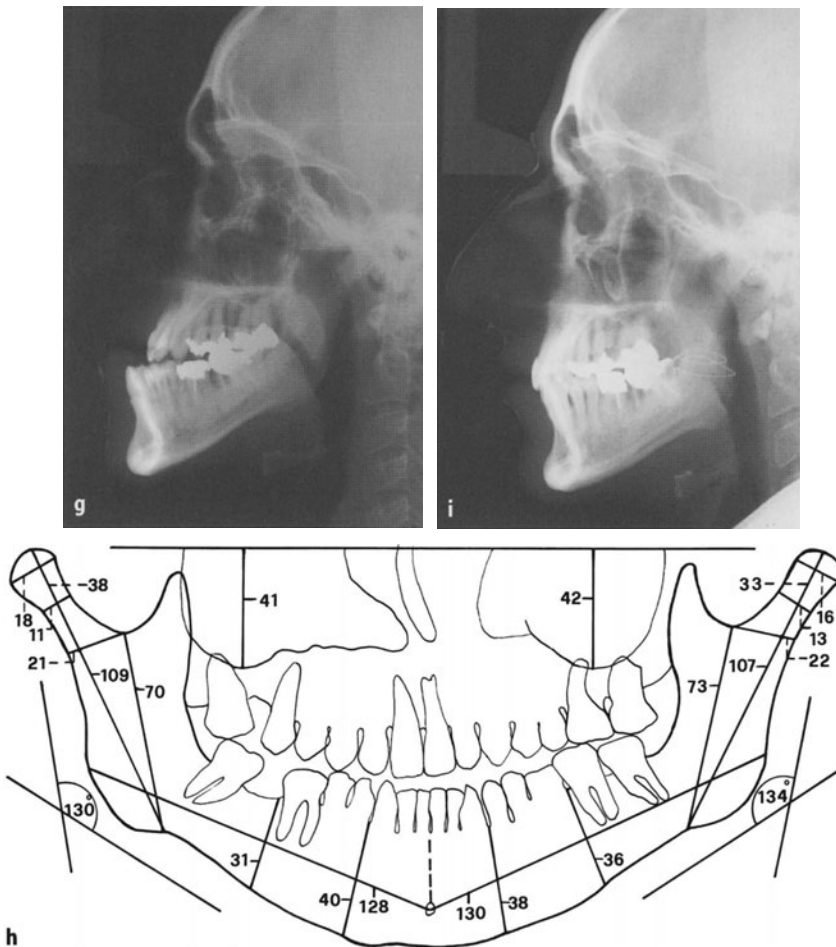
Bilateral H.E., developing after normal skeletal growth has ceased. g The lateral cephalogram shows that this massive very protruding mandible has rather stretched angles. h The measurements of the tracing of the panoramic radiograph confirm what it appears to show. i The lateral cephalogram taken 18 months after surgery shows a good facial skeletal relationship for a vertical profile type. The angles have improved remarkably
